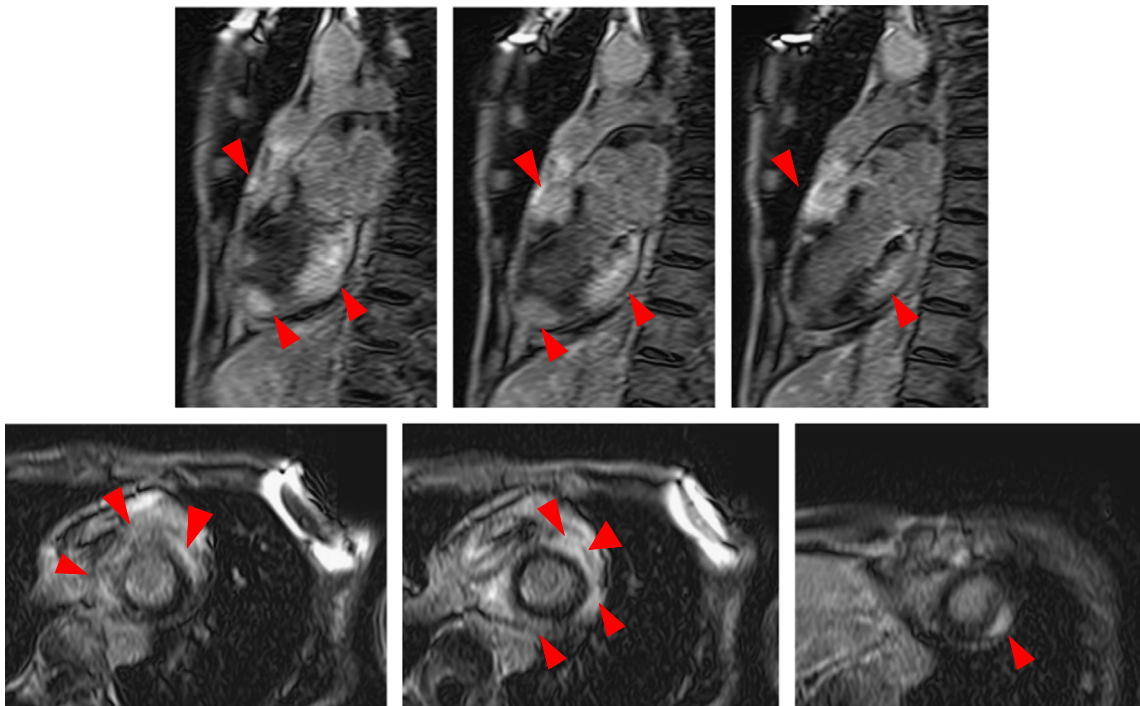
Cardiac MRI with gadolinium enhancement. Left and right ventricular function is normal, but multiple areas with delayed enhancement are observed in the basal anteroseptal, lateral, and apical regions (shown by red arrows).
